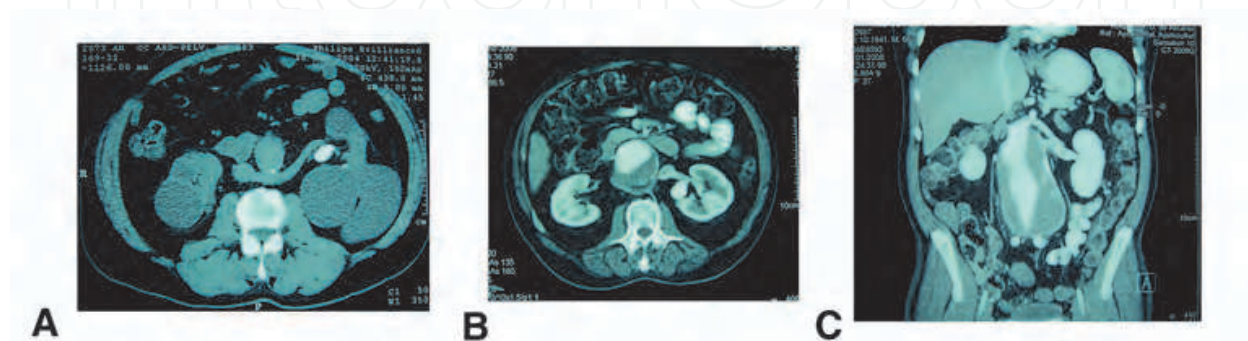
Left renal vein (LRV) anomalies CT. A, Retroaortic left renal vein type I. B, Retroaortic LRV type II. C, Circumaortic LRV.
